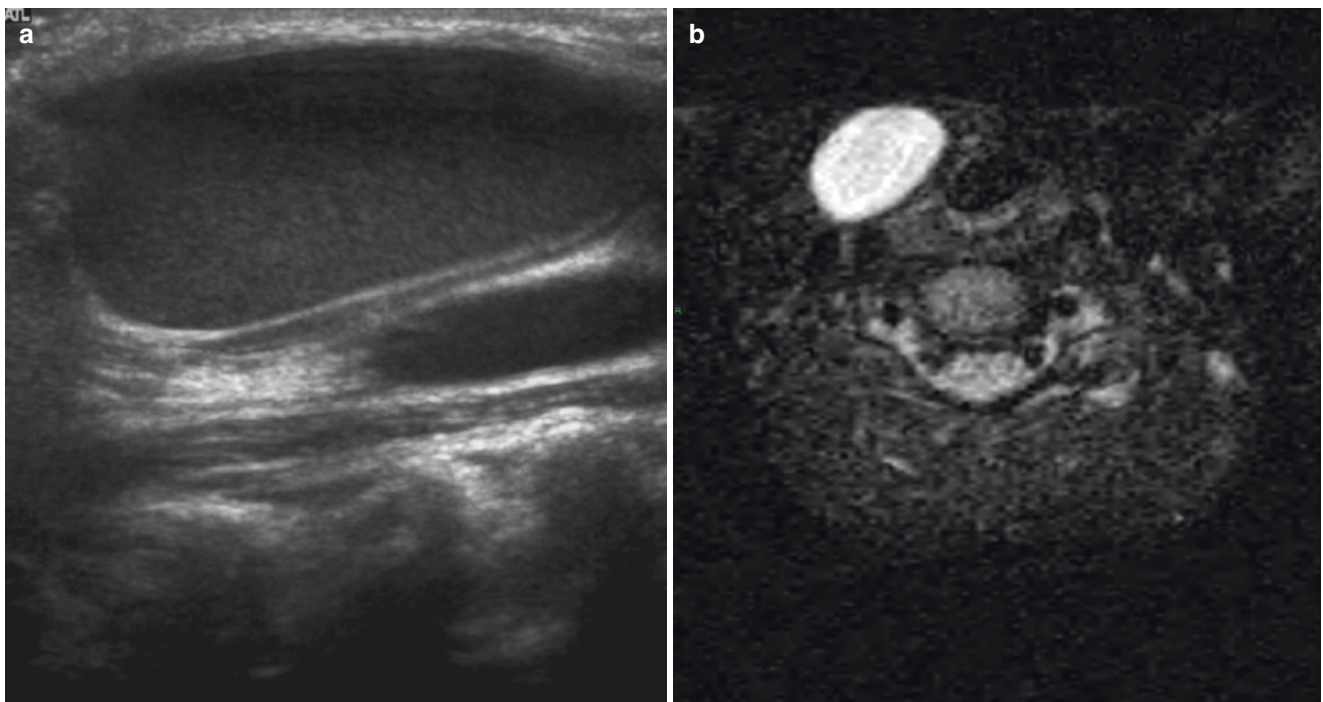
Right-sided second branchial cleft cyst. (a) Longitudinal ultrasound image shows an ovoid cystic structure with hypoechoic contents within the right side of the neck. (b) The cyst is hyperintense (bright) on an axial T2 fat-saturated MR image
